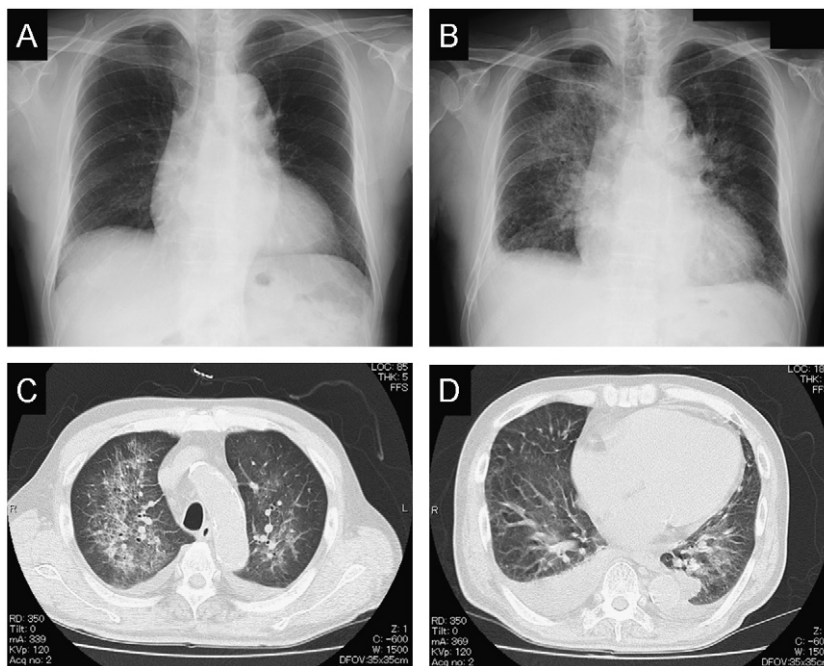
Chest radiography and computed tomography. (A) Chest radiograph before bepridil administration on the third hospitalization showed cardiomegaly (cardiac to thoracic width ratio: 57%) without pleural effusions and cephalization of pulmonary vessels. (B) Chest radiograph on the 12th day after bepridil administration showed bilateral pleural effusions and an interstitial pattern dilated from the pulmonary hilum. (C, D) Chest CT scan on the 12th day after bepridil administration revealed pleural effusion, patchy subpleural ground-glass opacities, consolidation, and diffuse linear opacity in the bilateral lung fields.
